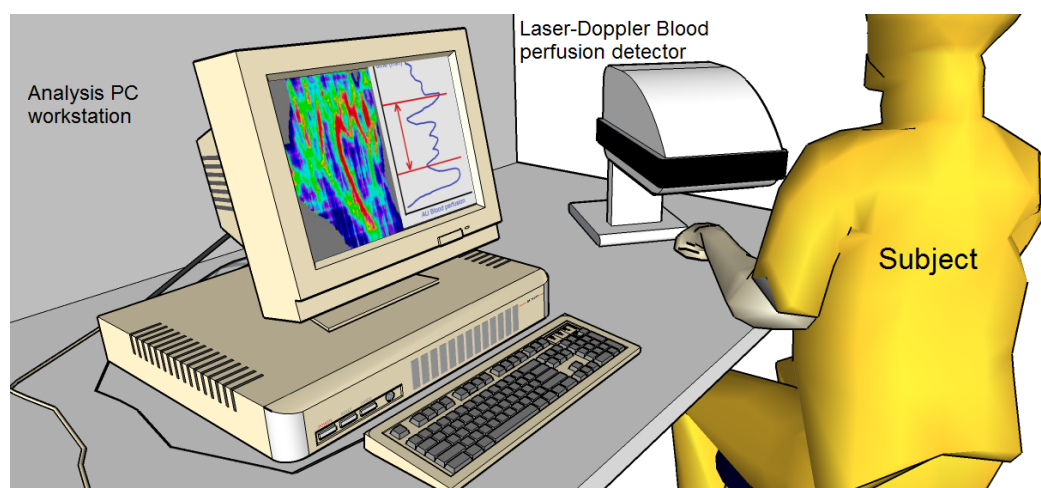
First measurement setup of the Doppler-laser blood perfusion imaging system prototyped by OxyLab® LDF instrumentation (Florida, USA), where the laser irradiation of the field of view and sensing temperature changes of blood flow using Doppler flowmetry unit.
